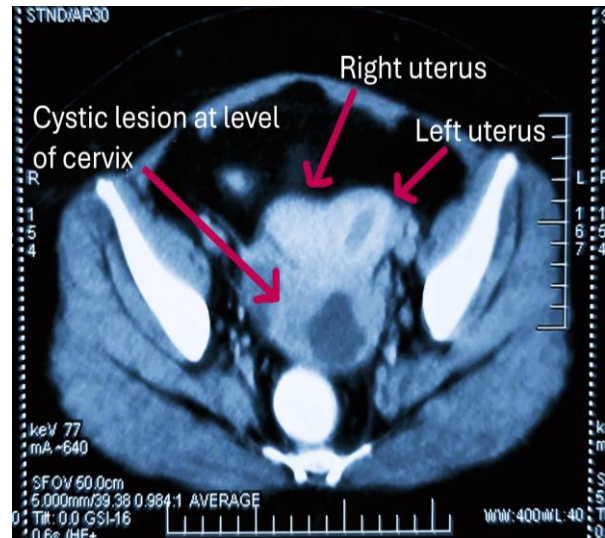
CT scan image showing didelphys uterus with collection at the level of uterine cervix communicating with uterine cavity
